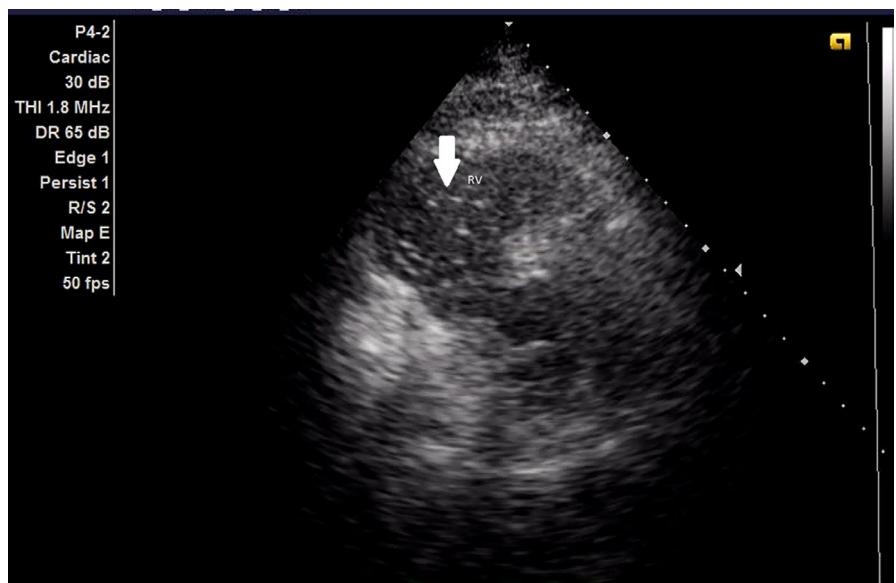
Patient's TTE before HBOT: microbubbles (Arrow) in the right ventricle. (TTE, transthoracic echocardiography; HBOT, hyperbaric oxygen therapy; RV, right ventricle)
